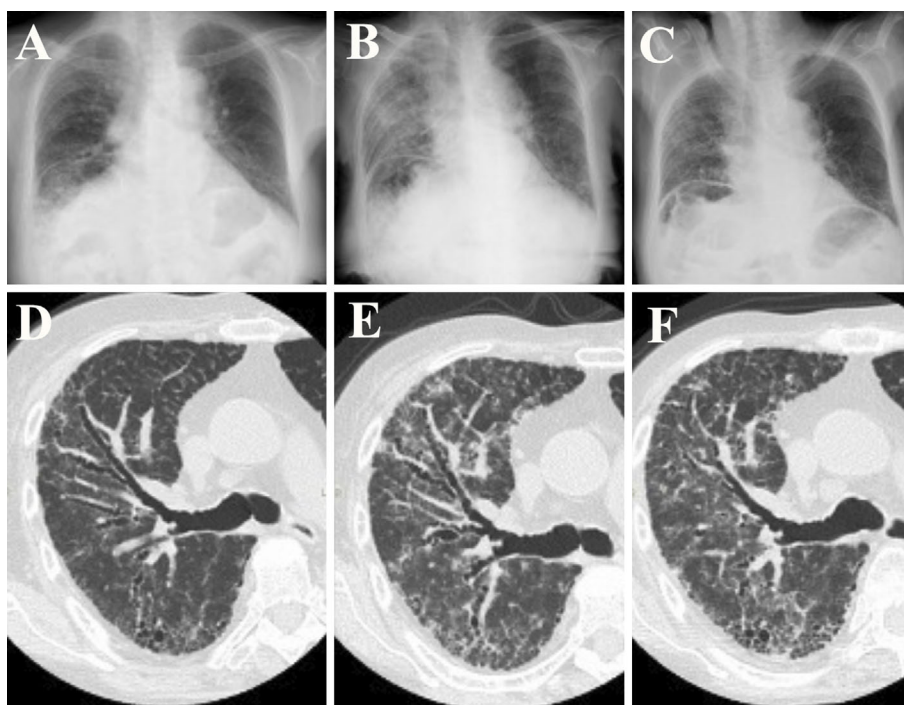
Lung involvement visible on chest X-ray radiography and computed tomography (A, D) before VZV infection, (B, E) at the onset of VZV infection, and (C, F) after treatment with amenamevir. VZV: varicella zoster virus
